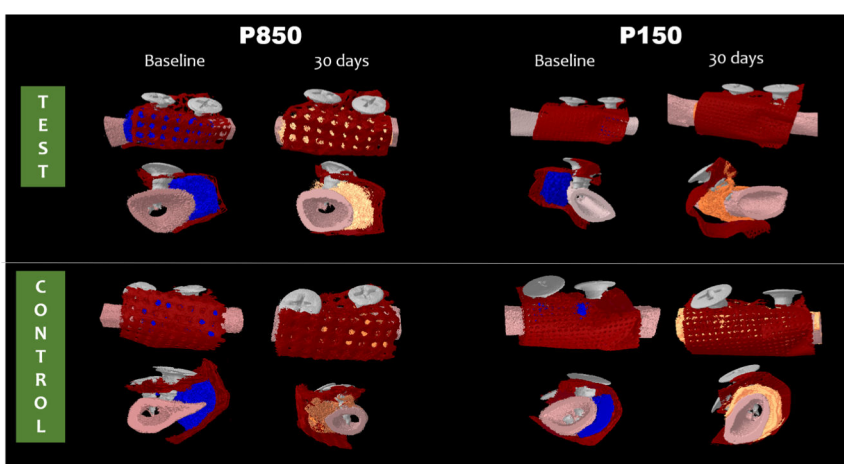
Micro CT 3D images of 850 and P150
